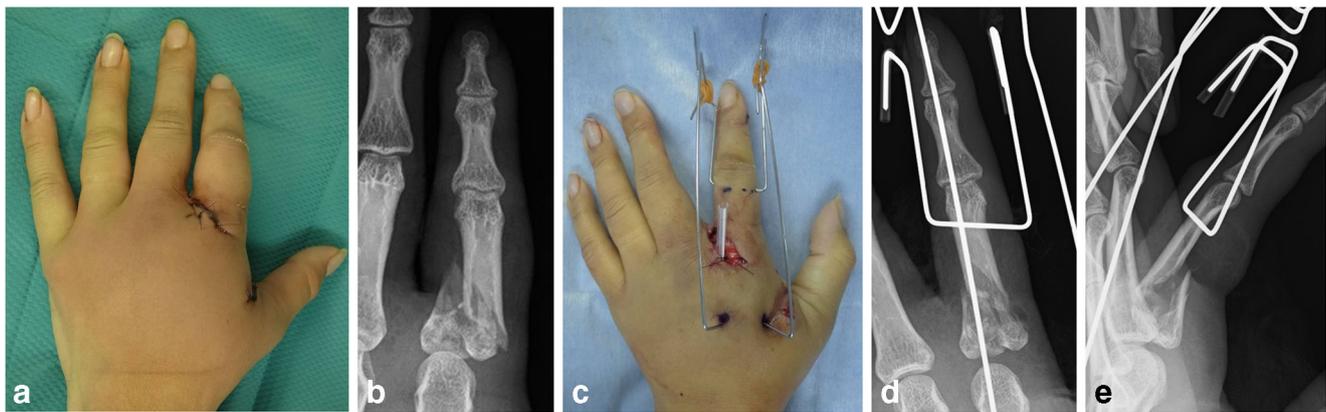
Macroscopic findings and plain radiography at the initial presentation and after debridement and external fixation. Macroscopic photograph (a) and plain radiography (b) at the initial presentation.
